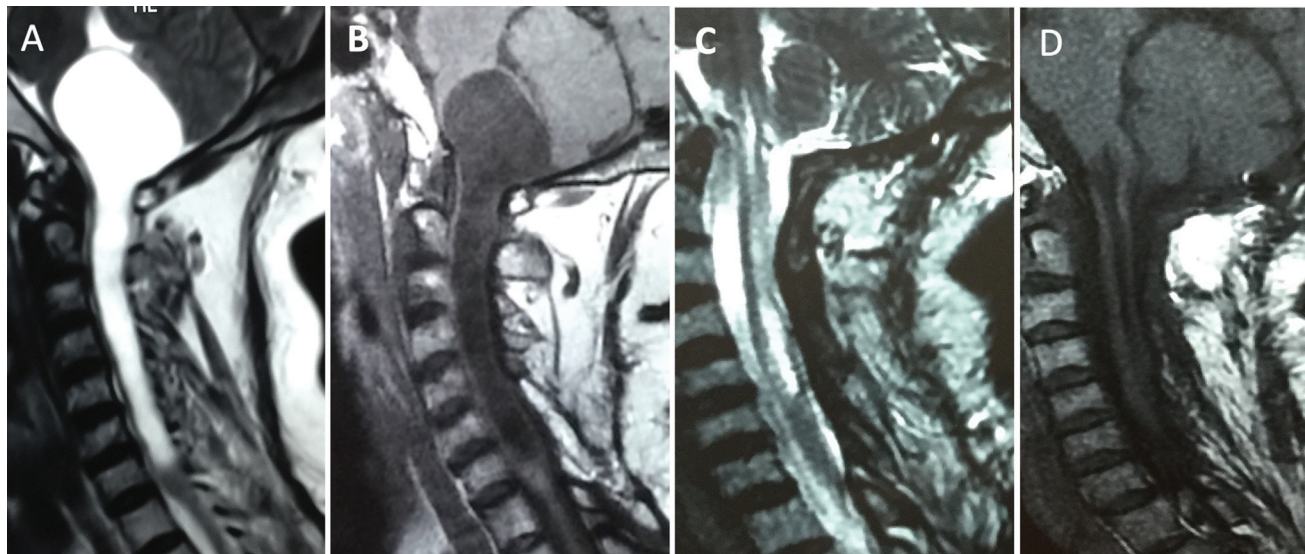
Magnetic resonance imaging (MRI) cervical spine with craniovertebral (CV) junction sagittal view showing intramedullary cystic lesion extending from the pontomedullary junction to the C7 level which appears hyperintense on T2-weighted image (A) and hypointense on T1-weighted image (B). Postoperative MRI cervical spine with CV junction sagittal view showing near-complete resolution of the cystic lesion on T2-weighted image (C) and T1-weighted image (D).
